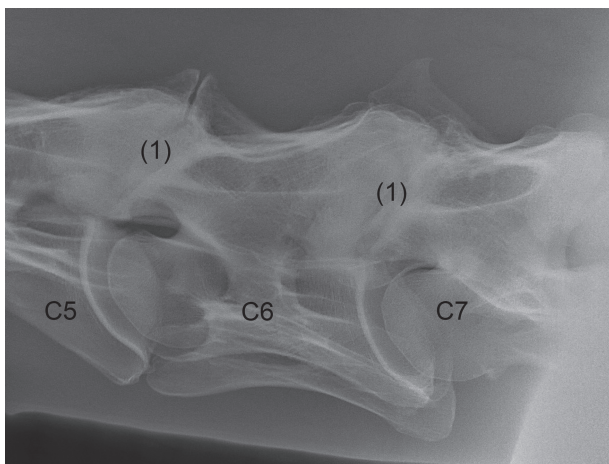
Lateral (side-view) radiograph of the lower neck of a 17-year-old gelding with neck pain. Marked arthritis is associated with the joint spaces (articular facets – 1), especially between the fifth (C5) and sixth (C6), as well as sixth and seventh (C7) vertebrae.
